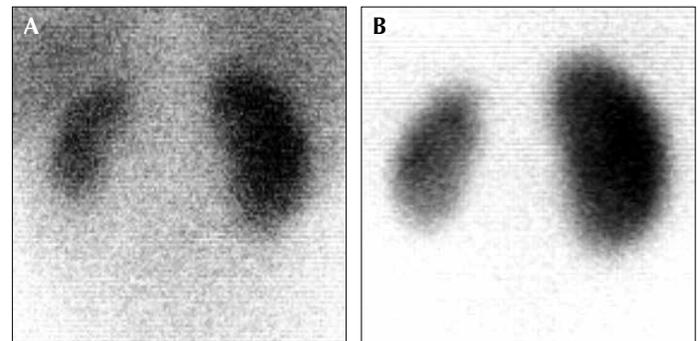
A 12-year-old girl with a history of grade III VUR in the left kidney had undergone ^{99m}Tc -MAG3 (A) and ^{99m}Tc -DMSA (B) scintigraphy within two weeks. According to the scoring system, it was evaluated that the left kidney had score of 7, whereas the right kidney had a score of 0
